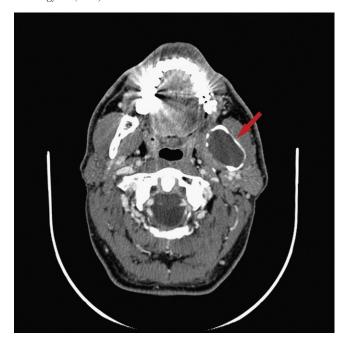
Computed tomography of the neck with intravenous contrast showing an expansive lesion in the mandible (case 3).
